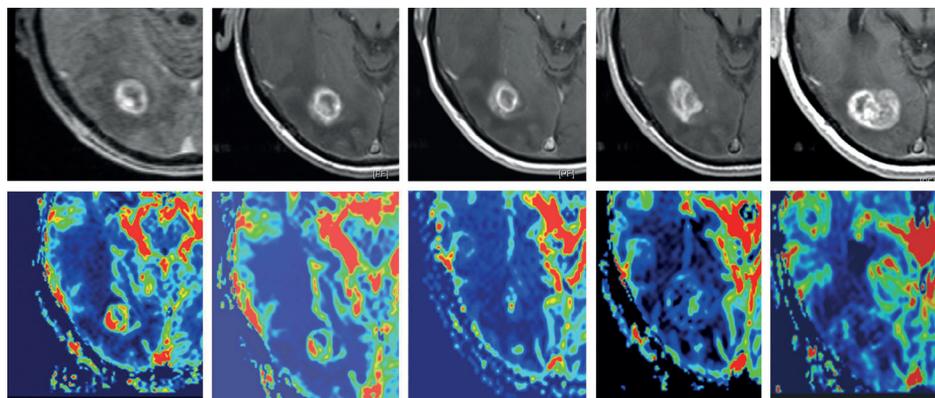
Five consecutive non co-registered MRI scans of patient 5. In the upper row the non co-registered MRI scans and in the lower row the color maps of the corresponding slices of the perfusion MRI scans, from left to right before SRT and 1, 3, 6 and 8 months after SRT.
